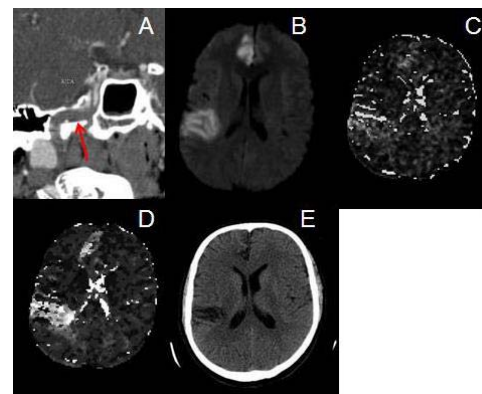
(A) Total occlusion of right intracranial ICA (arrow), (B) DWI showing acute strokes in the posterior branch of right MCA and right ACA territories, (C) Acute MTT and (D) acute Tmax matching DWI lesion. (E) Follow-up CT showing no lesion growth.
